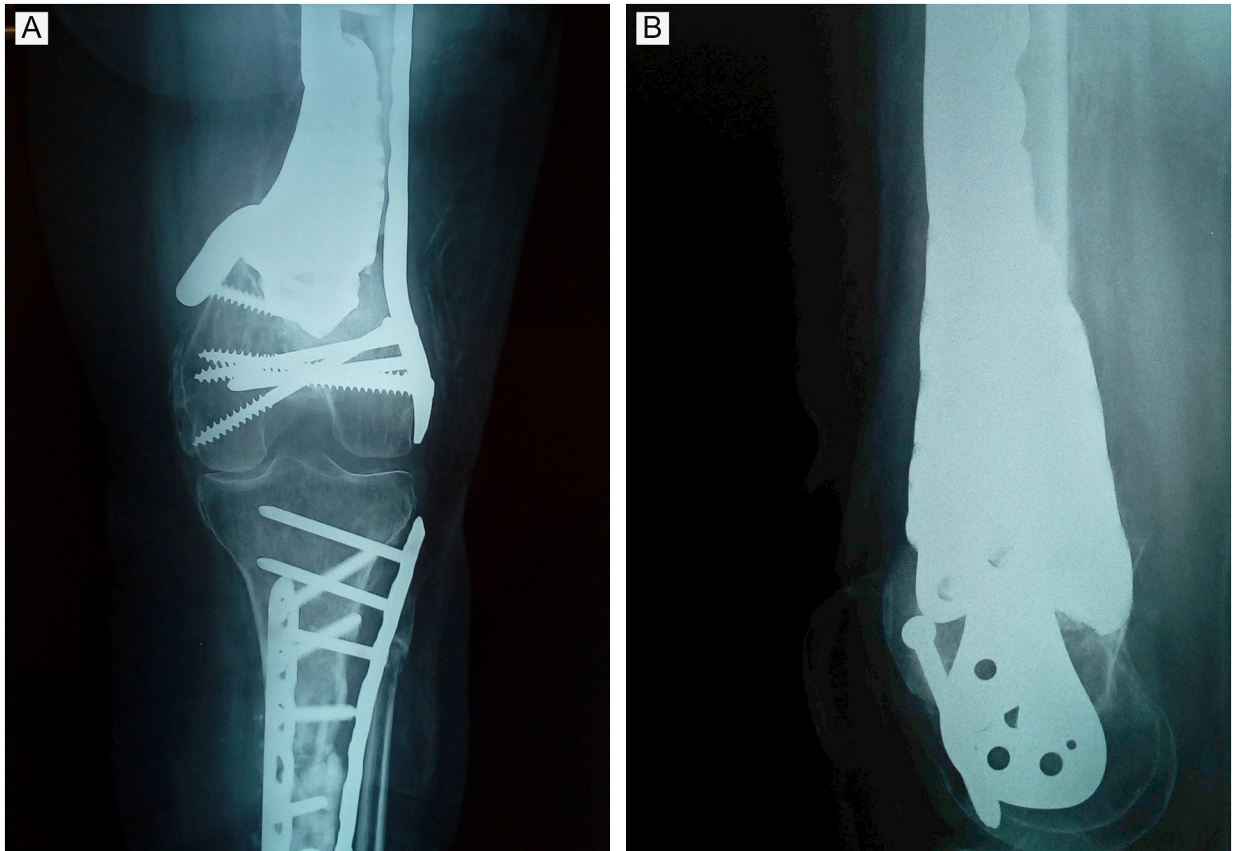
A and B. AP and lateral radiographs showing full osseointegration of the 3D printed implant in the femur 3-months postoperatively. Osseointegration in bone - EPORE material bone interface junctions are scored 4/4 (2 points on AP and 2 points on lateral film). Based on the on-growth grading system a stage 4 osseointegration, reveals the highest grade of union.
